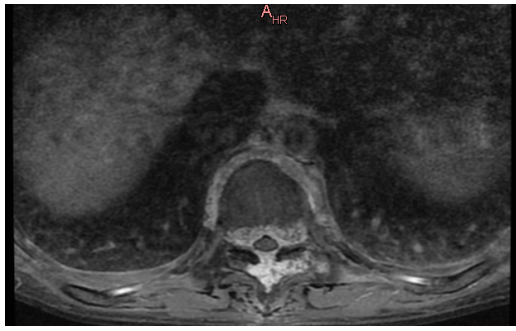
CD MRI Axial section: bone structure is inhomogeneous in the T9 vertebra (body, pedicles, transverse and spinous processes, upper and lower joint processes) by the presence of predominantly osteolytic lesions, associating the visualization of bone trabecula suggestive of hemangioma vertebral.
